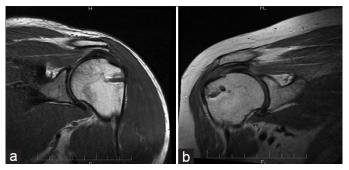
MRI of healed patients at follow-up. (a) Sugaya Type I, sufficient thickness with homogenously low intensity; (b) Sugaya Type II, sufficient thickness with partial high intensity.
